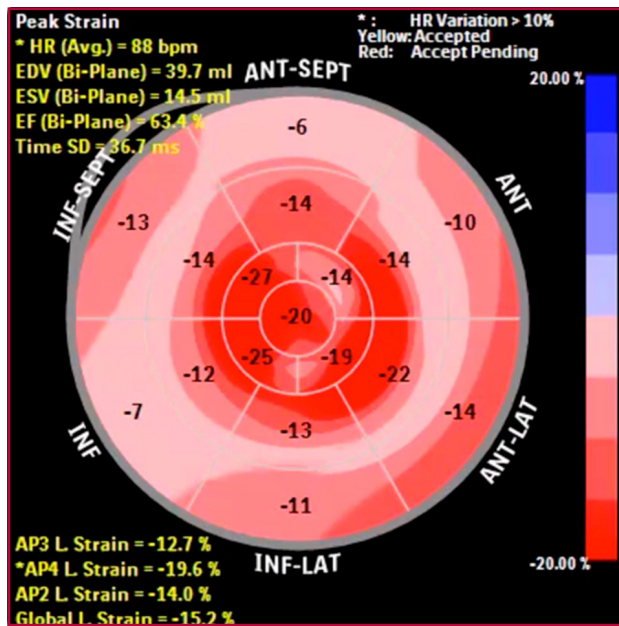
Echocardiogram. Strain pattern with characteristic "cherry on top" image, suggestive of cardiac amyloidosis.
